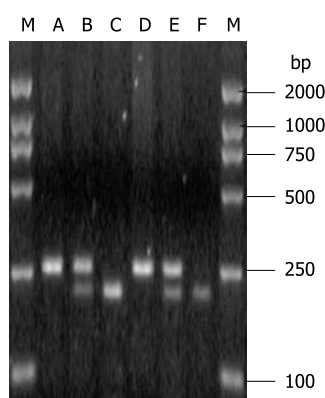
IL-4-589 C/T SNP. M: Marker; A and B: TT mutant genotype; C and D: CT genotype; E and F: CC wild-type genotype.
